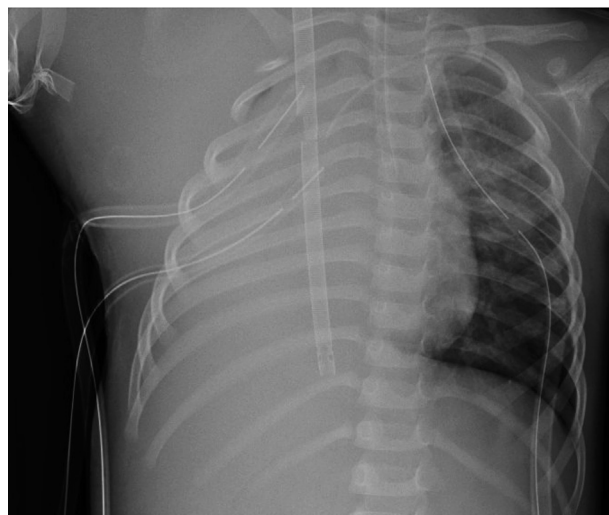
Case 1: Portable anteroposterior chest x-ray demonstrating the endotracheal tube in the left mainstem bronchus, a venous ECMO cannula, 3 pleural chest tubes, a left upper extremity peripherally inserted central catheter, and a right axillary surgical drain.
